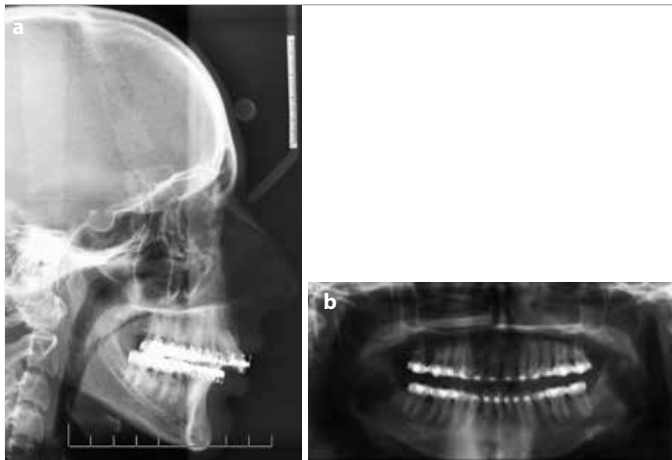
a, b. Preoperative lateral cephalometric (a); panoramic radiographs (b)
